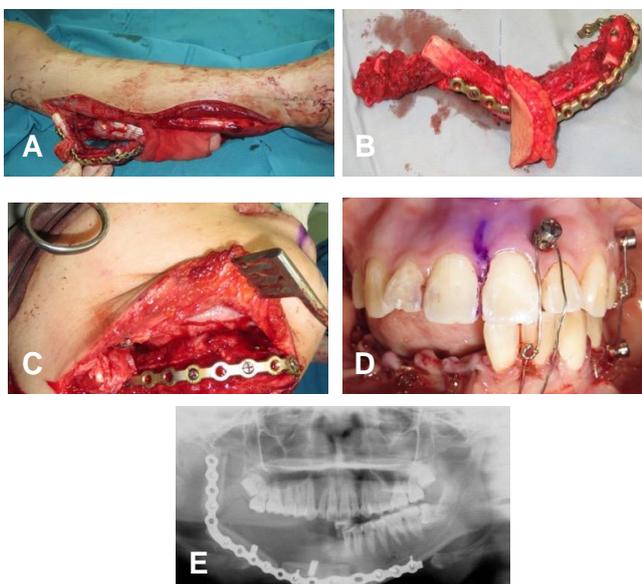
Mandible reconstruction using fibula (A) Molded fibula based on the prebended plate, (B) Fibula and skin paddle already disconnected, (C) Fibula segments transferred to mandible, (D) Fixation of the jaw, (E) Panoramic radiograph post operative.
